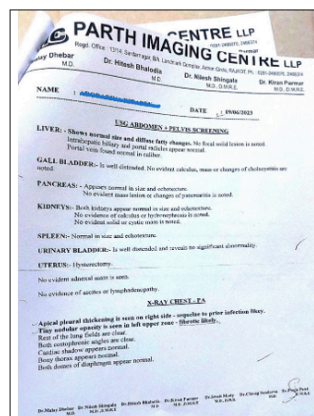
X-ray report dated on 09/06/2023
